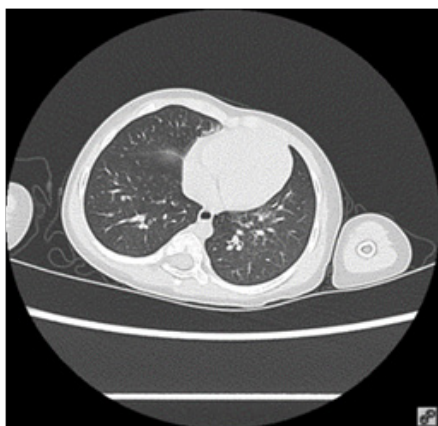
Chest CT of WQY (2 years and 5 months old) with a negative nucleic acid test of novel coronavirus.
